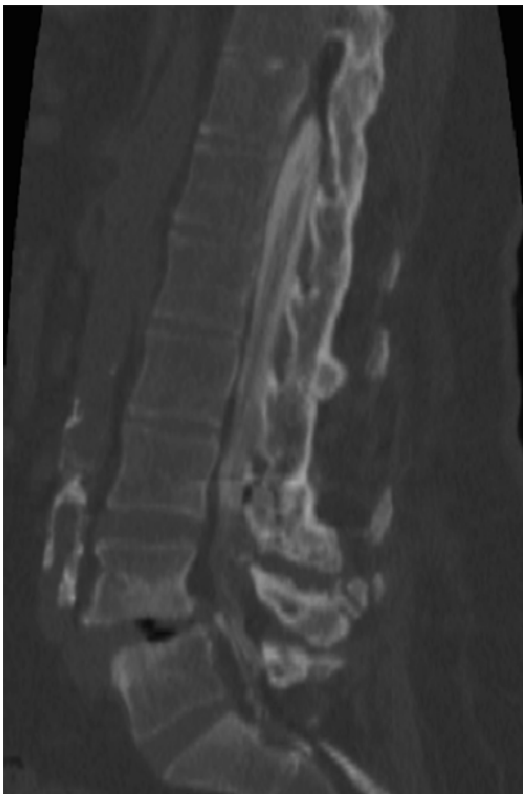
Preoperative computed tomography sagittal view demonstrating spondylolisthesis at L4-5 below long fusion construct with spinal stenosis
